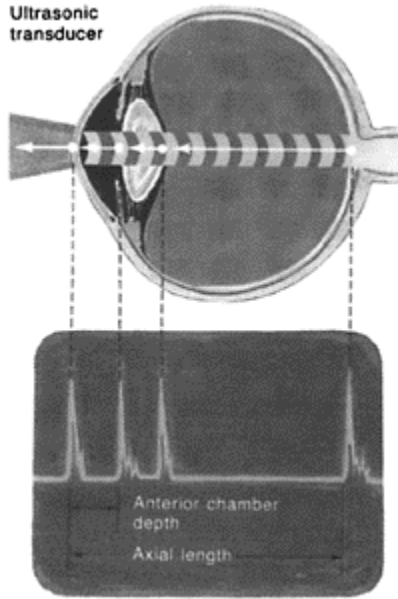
A-scan ultrasonography for IOL power calculation and axial length measurement of globe (*Courtesy: Ciba Geigy Clinical Symposia*)
